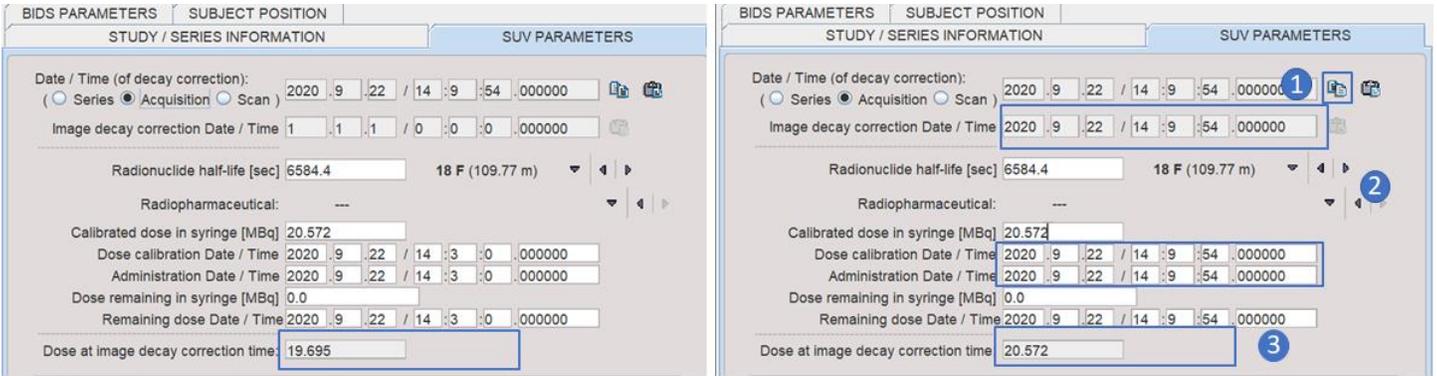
PMOD SUV Parameters before adjusting (left) and after adjusting (right) dose information. Dose at image decay correction time is the activity that will be used in the SUV calculations within PMOD. To adjust the Dose at image decay correction time the reference time needs to be adjusted by selecting the button 1) copy dose to fields. Check that the Image decay correction date/time and Dose calibration/administration time fields are now the same as the Acquisition time. The Dose at image decay correction time (3) should now match the value that was entered in the Albira Suite study registration.
